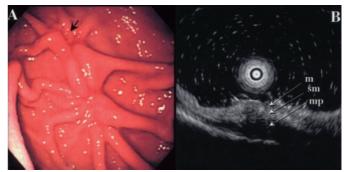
Gastroscopic examination 4 weeks after the second one; red ulcer scar is demonstrated. (A), The arrow points to the scar of jumbo biopsy. (B), Endoscopic ultrasonography revealed Ul-III ulcer scar. m, mucosa; sm, submucosa; mp, muscularis propria.
